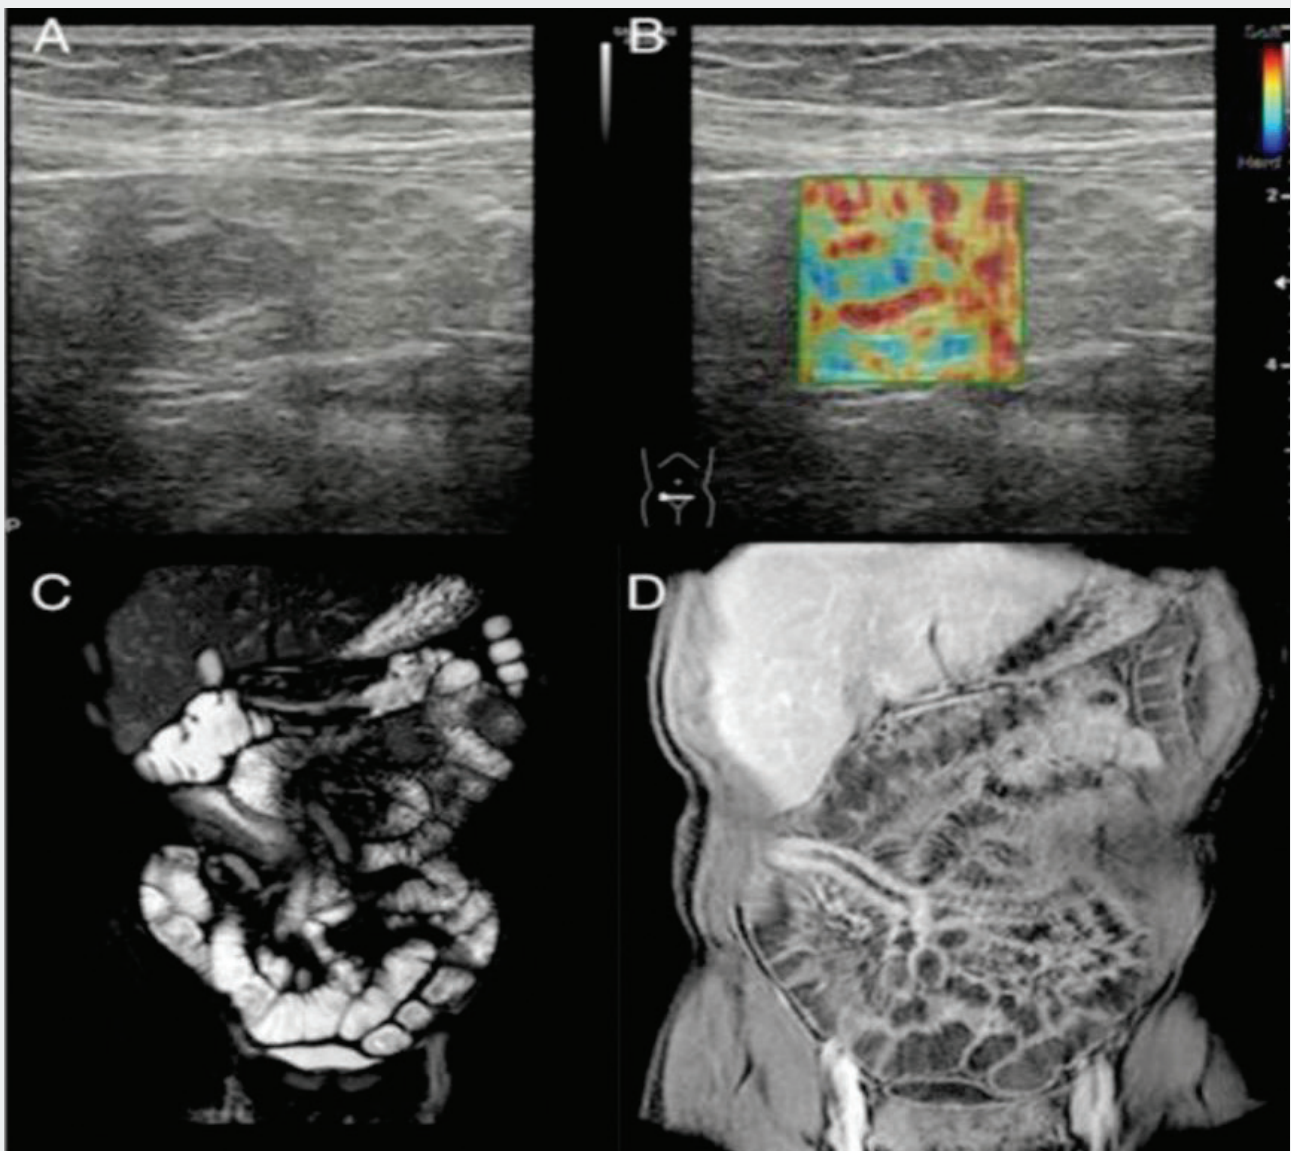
Transverse US-scan of the last ileal loop in a 26-years old female shows wall thickening in which stratification was completely lost and hypo-isoechoic appearance of perivisceral fat. The gray scale (A) findings and US-SE (B) aspect performed at this level are suggestive for fibrotic pattern. The MR study (C and D) confirmed these suspicions: T2-weighted coronal view revealed hypointensity of the bowel wall, T1-weighted coronal post-contrast showed enhancing of the bowel wall without stratification.
